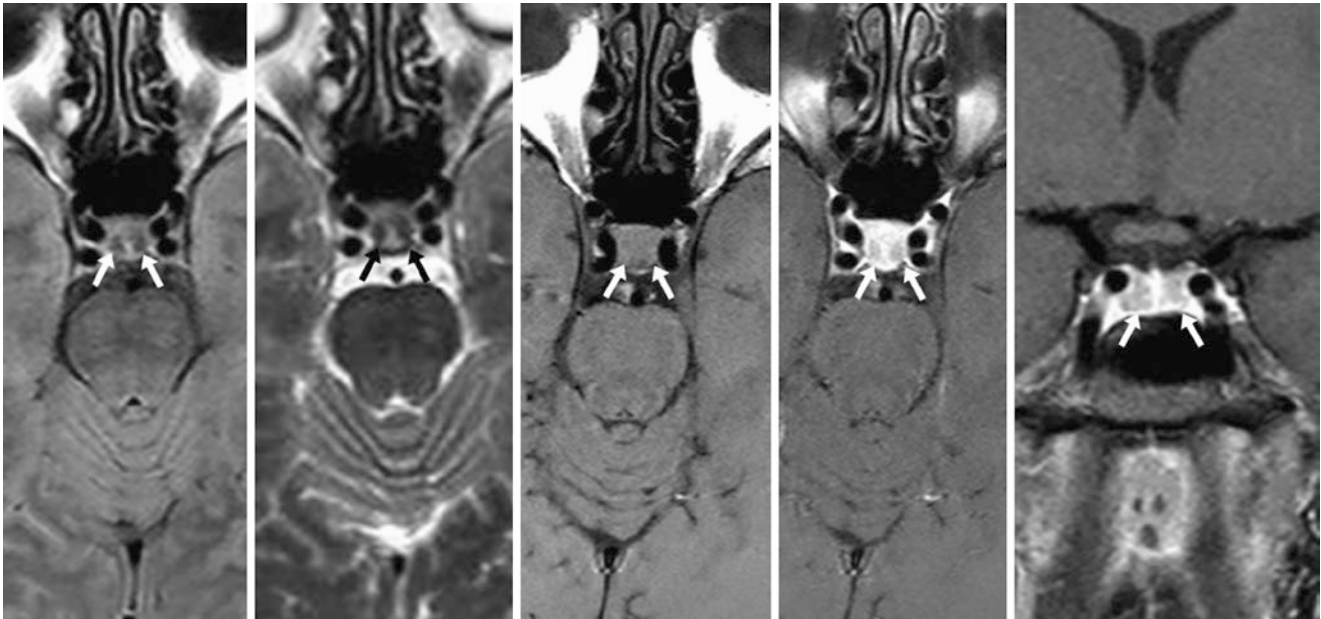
Normal lateral anterior lobe enhancement on delayed images. In a 36-year-old female with vertigo, the lateral anterior lobes (arrows) are hypointense prior to contrast on 1.5 T MRI axial FLAIR (left) and T2WI (left middle) but not on T1WI (middle). Postcontrast
